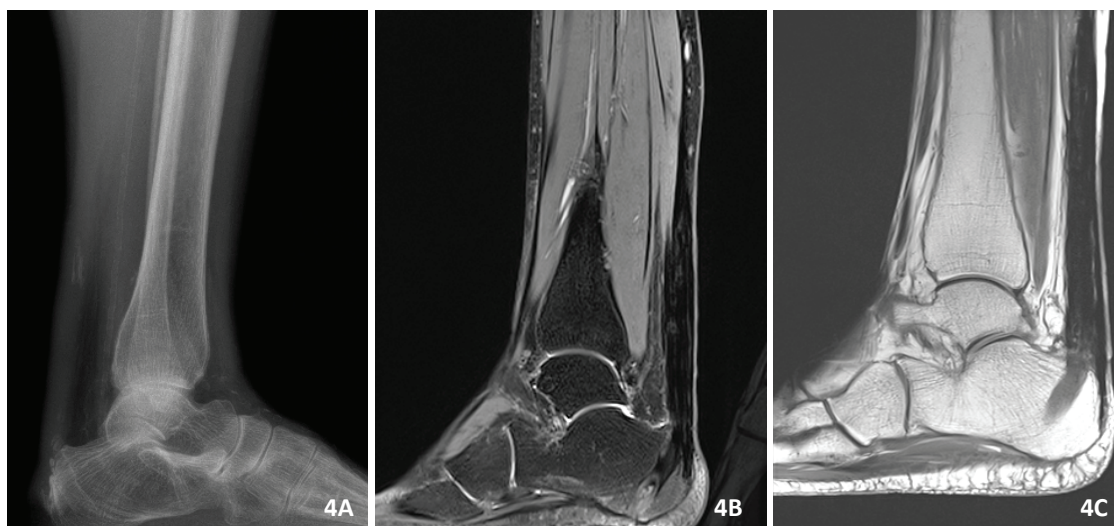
3-year postoperatively X-ray image of the left Achilles tendon; 4B and 4C - MRI scans of the reconstructed left Achilles tendon.
